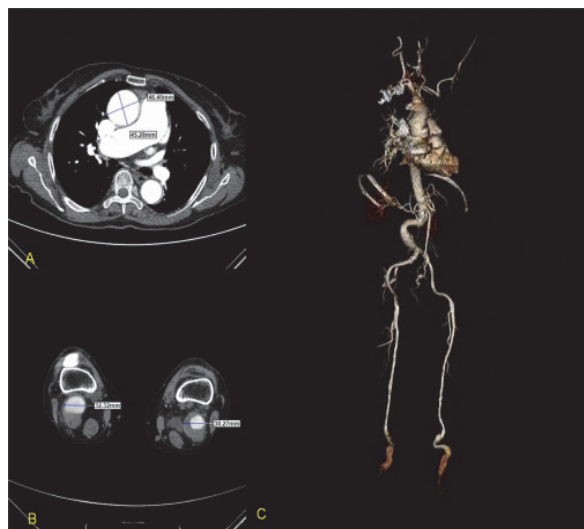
A) Aneurysmic ascending aorta and B) CT image of the popliteal artery; C) 3D image of the aneurysmic arteries and other segments.
